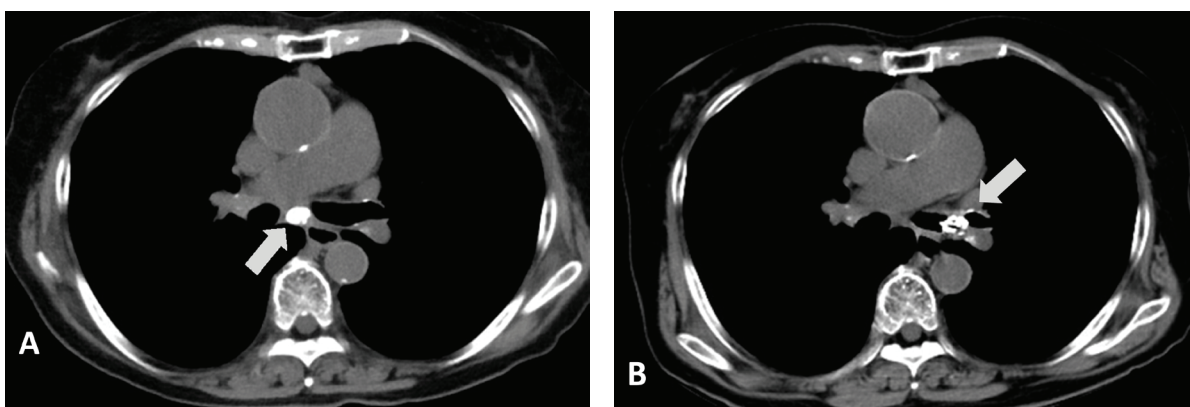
A. Calcified subcarinal lymphadenopathy on chest CT 3 years ago. B. Broncholithiasis obstructing the left main bronchus during this hospitalization.
